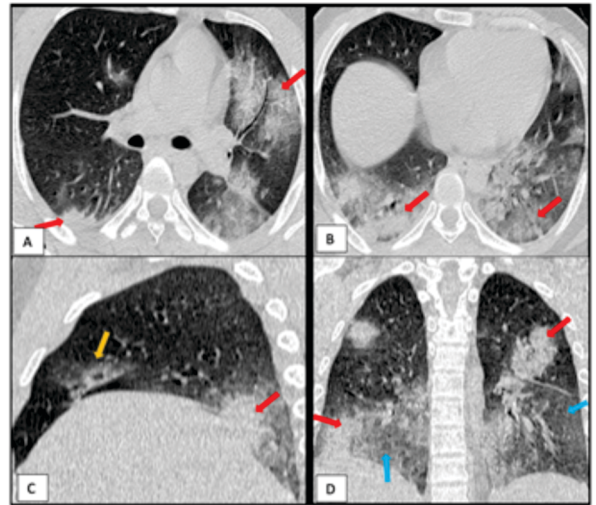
High Resolution Computed Tomography (HRCT) chest in a 30 year old male, 5 days after the symptoms appeared; in axial plane (A and B), sagittal (C) and coronal (D) planes- show bilateral patchy areas of consolidation (red arrows), ground-glass opacification with interlobular septal thickening- crazy paving pattern (blue arrows) and an area of faint ground-glass opacification in the right middle lobe with a ring of denser consolidation- reverse halo sign (yellow arrow).
